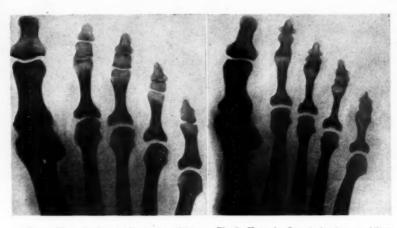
X-ray in Case 4 showing an oblique fracture of the proximal phalanx of the left middle toe.
